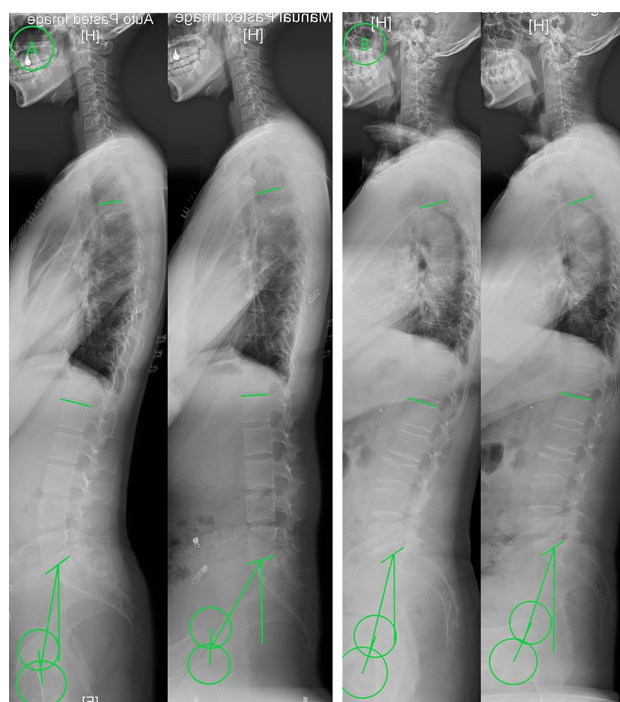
a The standing and sitting radiographs of 21-year-old female. When moving from standing to sitting position, SVA increased from -26.5 to 27.2 mm, PT increased from 9.5° to 32° , LL decreased from 50.5° to 17.2° , and TK decreased from 20.7° to 15.1° . B. The standing and sitting radiographs of 66-year-old female. When moving from standing to sitting position, SVA increased from -17.4 mm to 4.1 mm, PT increased from 14.1° to 18.3° , LL decreased from 49.8° to 39.1° , and TK decreased from 37.6° to 30.2°
